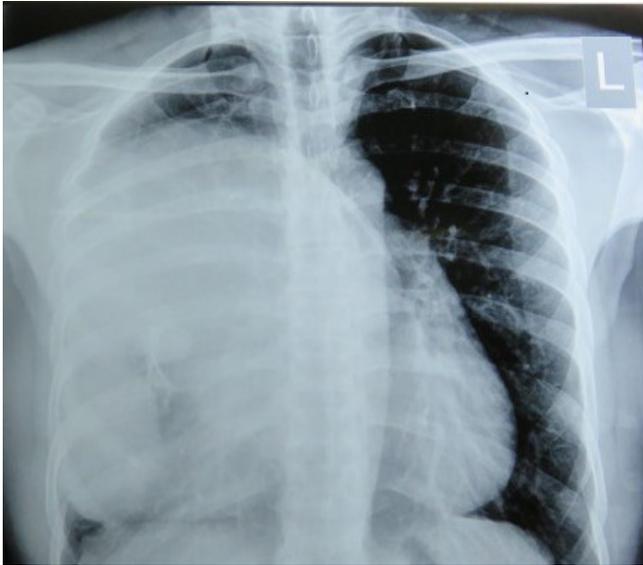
(A) Chest X-ray showed a large mass in Right thoracic cavity. (B) CT scan of the chest revealed a 20cm mediastinal mass and metastasis. (C) Tumor removed with thoracotomy.
